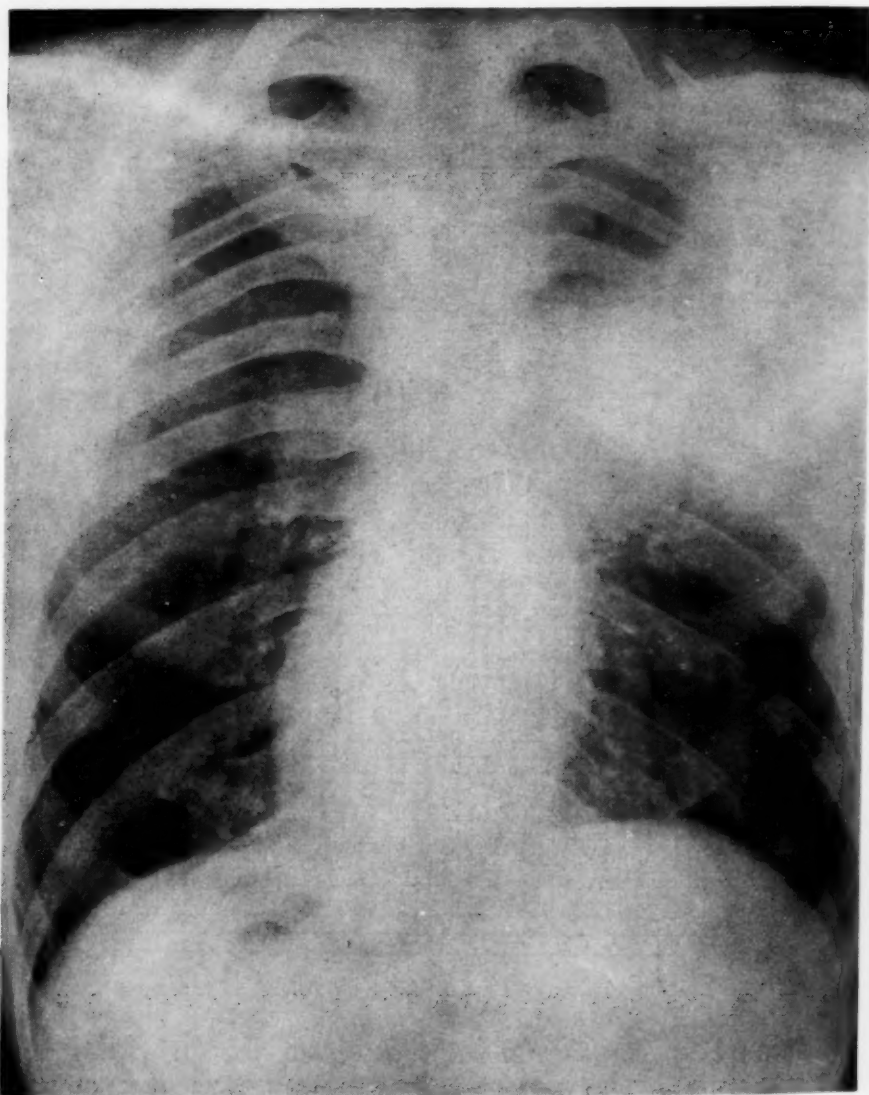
Roentgenogram of chest of Case 3, showing pulmonic consolidation in upper right lobe.
